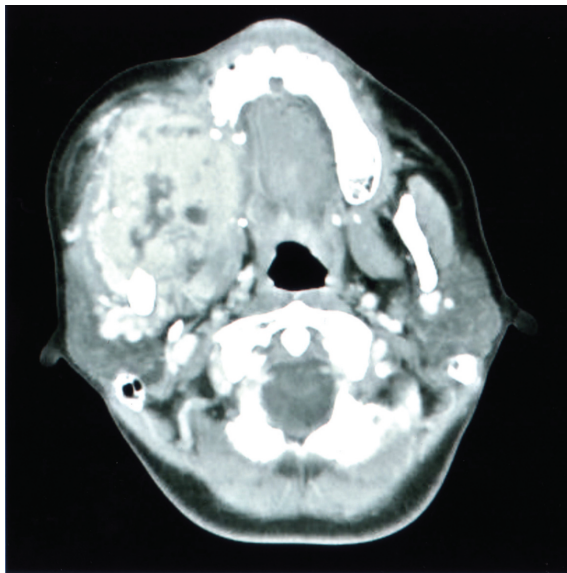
Preoperative CT reveals a heterogeneous tumor in the right buccal area. The tumor extends from the right inferior temporal fossa to the right submandibular area.
